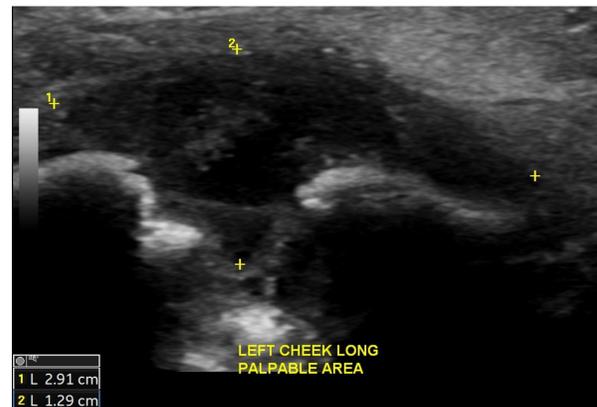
Ultrasound image using linear probe of facial swelling. Hypoechoic complex finding in area of interest with some internal debris. No evidence of cobblestoning to suggest overlying cellulitis. Differential is broad and dependent on location of finding. This includes infection, resolving hematoma, a brachial cleft cyst, or other developmental cystic structure.
